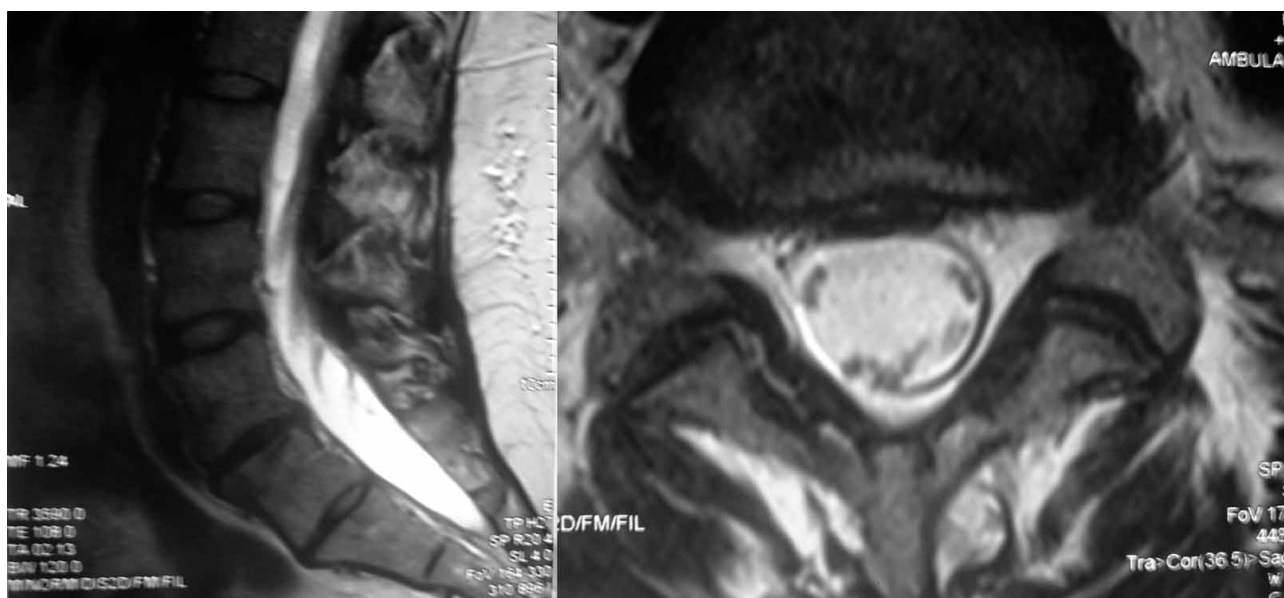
MRI taken after 12 months shows spontaneous regression, with development of degenerative changes of intervertebral segment.
